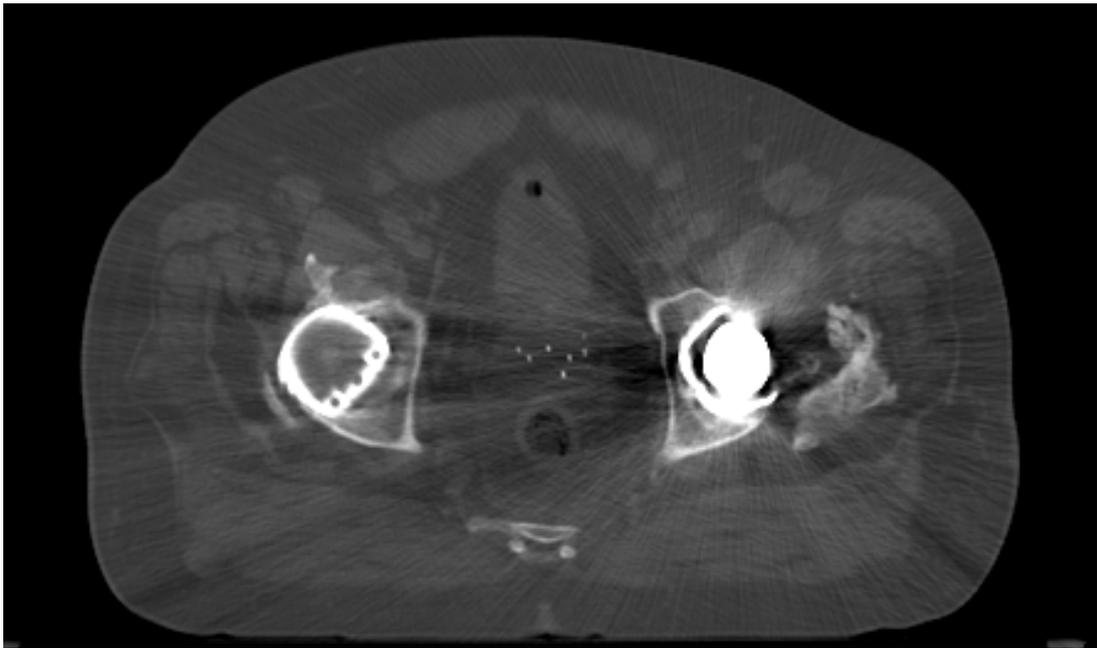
CT image with artifacts due to a hip prosthesis.
